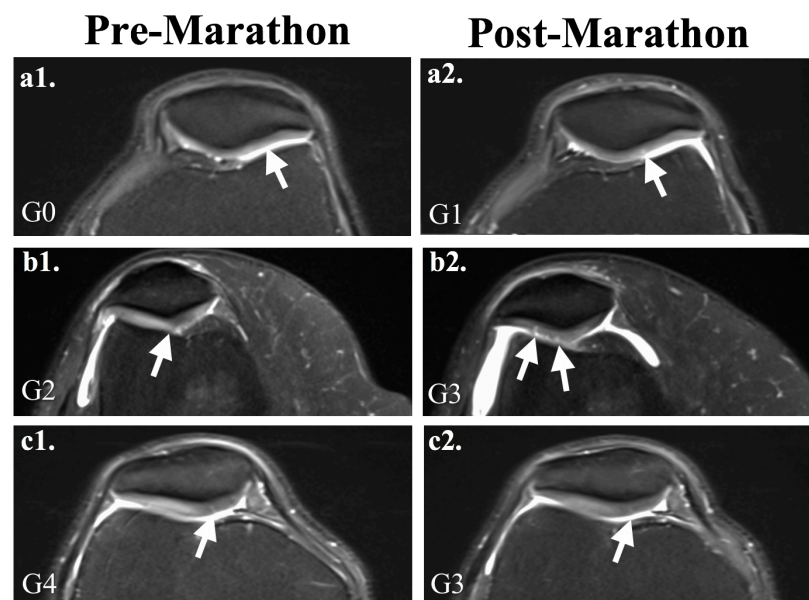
Axial proton-density fat-saturated MR images of 3 individual knees of 3 marathon finishers showing different patellar cartilage changes after the marathon: a1-2) appearance of small new cartilage abnormality in a previously normal knee; b1-2) progression of a pre-marathon abnormality to a higher extent after the run; c1-2) improvement in the extent of a high-grade pre-marathon abnormality after the run. The specific location of cartilage changes is indicated by arrows and the lesion grade (G) is included in the left bottom corner. The new modified Noyes scoring system was used.
